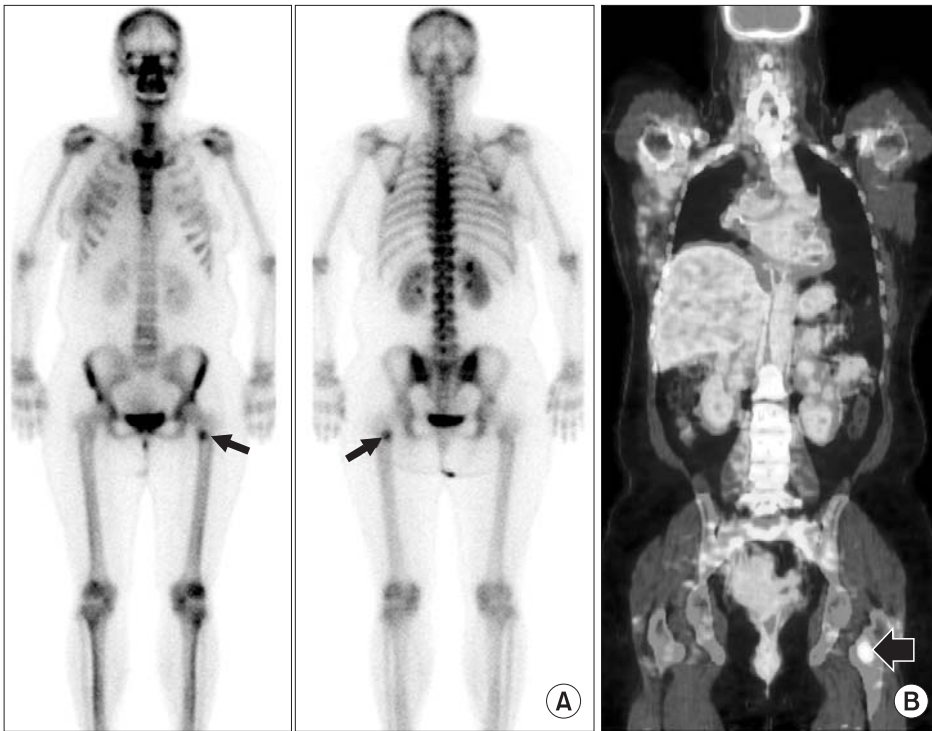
A 46-year-old woman with breast cancer. Bone scintigraphy (A) shows a focal hot uptake (arrow) in left proximal femur. PET/CT (B) shows a focal FDG uptake (arrow) in left proximal femur and was mis-interpreted as a single metastasis from breast cancer.
